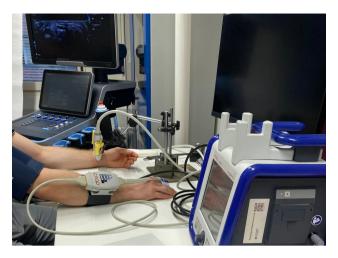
Setup of the validation experiments. The ultrasound probe was oriented transverse to the radial artery of the left wrist, held in position using a custom-made fixation device. The CNAP device was affixed to the proximal phalanges of the index and middle fingers of the right hand.
